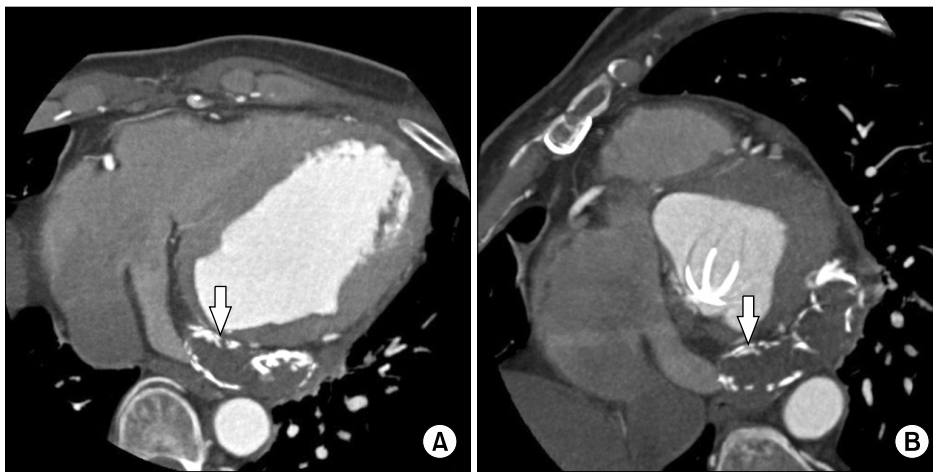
(A, B) Postoperative coronary computed tomographic angiography. There is no evidence of recurrence of the pseudoaneurysm. The arrows show no leakage at the closed aneurysmal neck.
